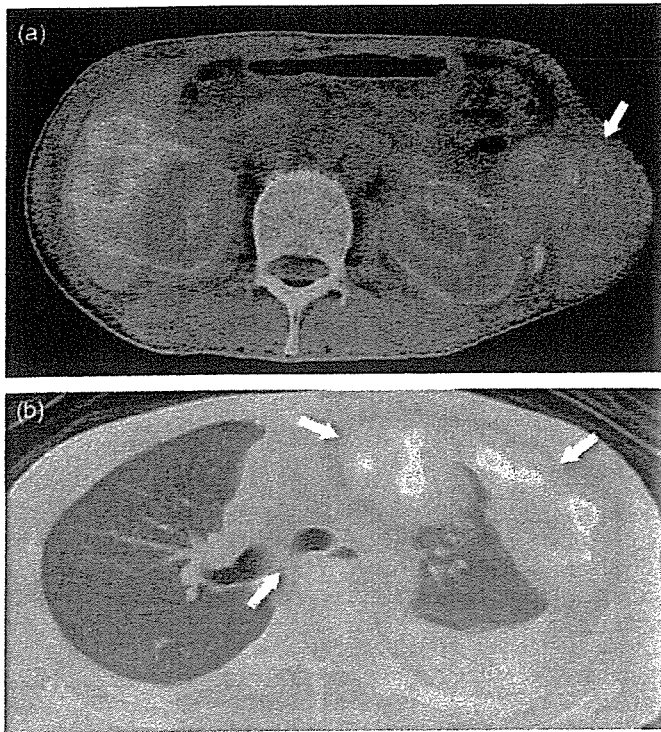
A 34-year-old man with clear cell sarcoma. (a) Transverse ^{11}C -choline positron emission tomography (PET)/computed tomography (CT) image depicting abnormal uptake in the tumor arising from the left lateral chest wall (arrow). (b) PET/CT image also depicts pleural dissemination and mediastinal lymph node (arrows). Follow-up findings in this patient confirmed the diagnosis.
